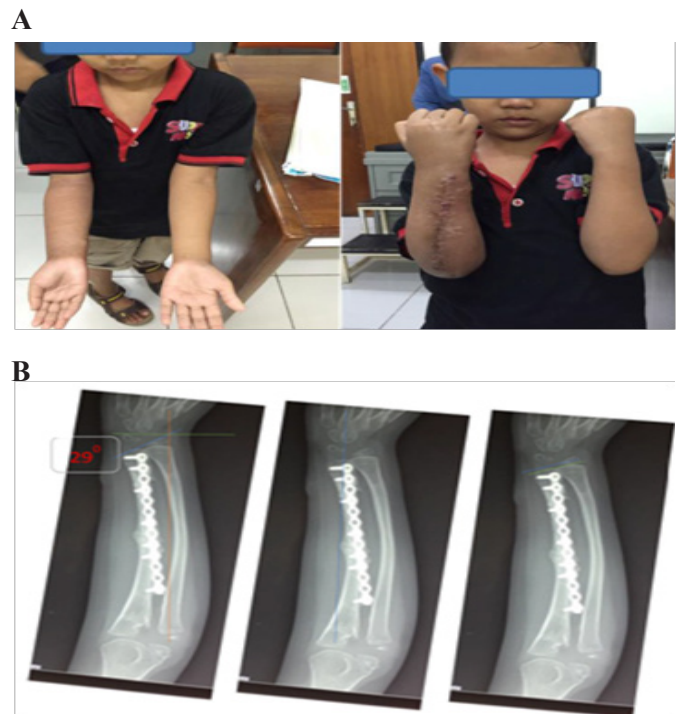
Clinical and radiographic photo of the right forearm in patient 2 A. achieved full range of flexion elbow after the operation. B. Radiographs after the operation with all of parameter was normal limit
